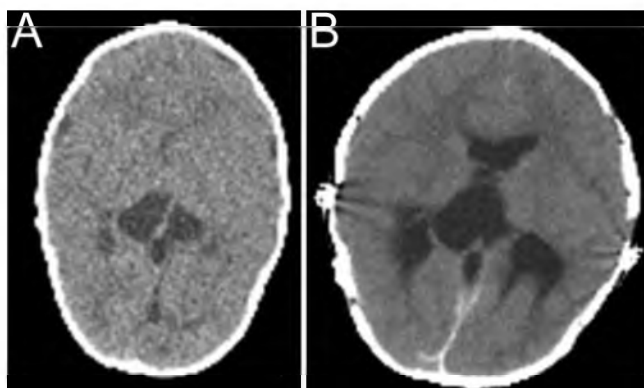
Axial CT scans without contrast enhancement obtained preoperatively (A) and on postoperative Day 1 (B) in a patient with shunt placement after craniostyostosis surgery. The postoperative CT scan shows significant enlargement of ventricles consistent with shunt malfunction.
